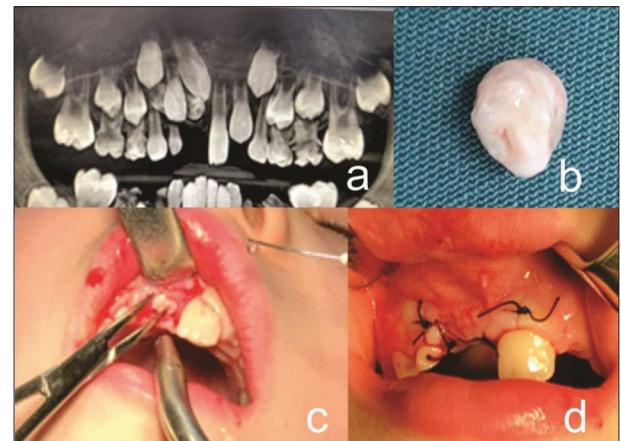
Unerupted tooth 11 (a – X-ray, b – extracted supernumerary tooth, c – extraction site, d – post-extraction suture)
